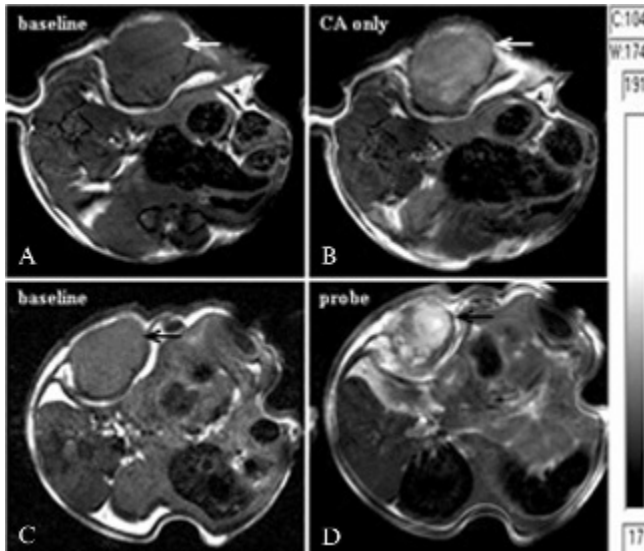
Comparison of the signal enhancement by contrast agent (CA) alone (A–B) and by the probe transferrin-liposome-nitrobenzoxadiazole-contrast agent ($\text{Tf}^{\text{NIR}}\text{-Lip}^{\text{NBD}}\text{-CA}$) (C–D). The magnetic resonance images (MRIs) are from the same tumor, with an interval of 72 hours between studies with the probe and with CA alone. A stronger, heterogeneous signal enhancement is achieved with $\text{Tf}^{\text{NIR}}\text{-Lip}^{\text{NBD}}\text{-CA}$ over CA alone. The MRI parameters are the same as for Figure 3.
